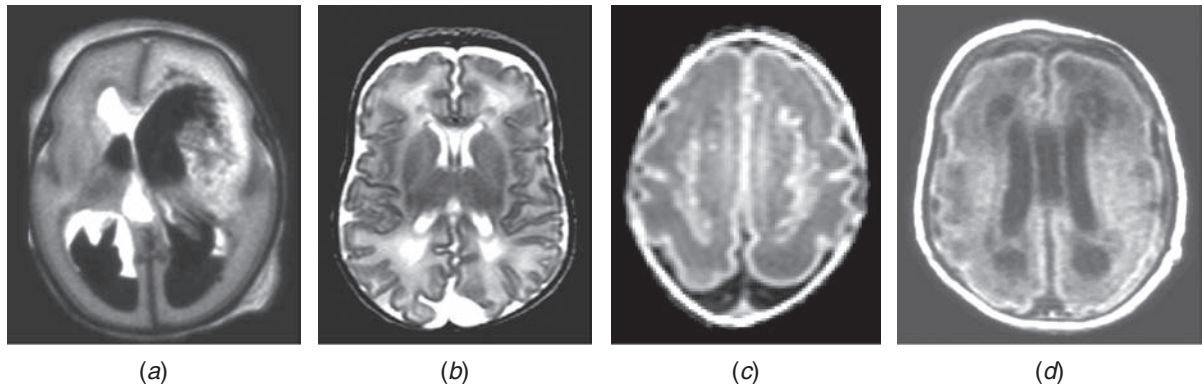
White matter lesions in the preterm infant. (a, b) T2- and (c, d) T1-weighted images. (a) Bilateral intraventricular hemorrhage with a large left-sided hemorrhagic venous infarction. (b) Diffuse excessive high signal intensity in the white matter of a preterm infant at term-equivalent age. (c) Severe bilateral punctate lesions in the white matter of the centrum semiovale. (d) Bilateral periventricular cysts in a preterm infant with periventricular leukomalacia.
